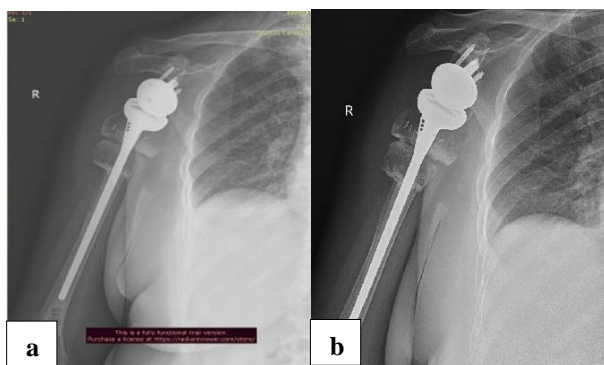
(a and b): X-ray of left humerus of patient A at 10 months (left) and at 2 years (right) post tumor resection and cemented RTSA and allograft bone blocks augmentation showing further sclerosis of bone blocks with no clear evidence of bone resorption or hardware complications.
